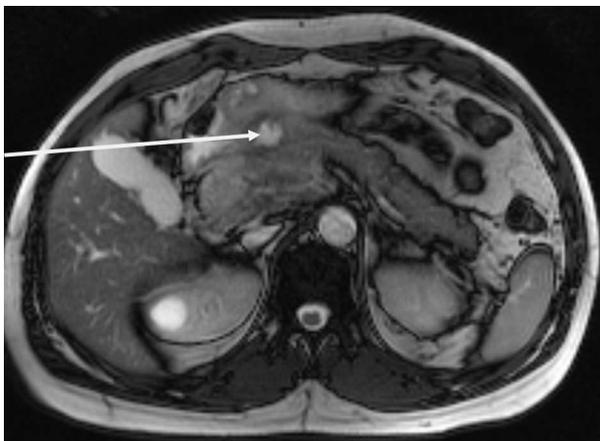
MRI showing a posterior lesion penetrating into the pancreas (arrow).
